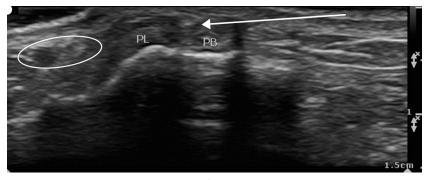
Sonographically guided injection of peroneal tendon sheaths at location distal to lateral malleolus. Imaged short axis to PL and PB tendons, needle approach in plane with transducer. Arrow delineates path of needle. Oval encircles sural nerve and vein. Left, inferior and posterior; right, anterior and superior.
